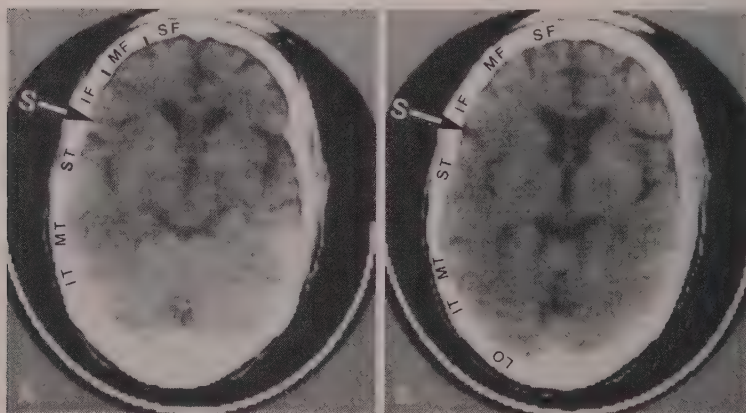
Gyral Anatomy.* A, Non-contrast-enhanced CT scan along reference line 3 clearly delineates the superior frontal gyrus (SF), middle frontal gyrus (MF), inferior frontal gyrus (IF) and the Sylvian fissure (arrow S). Compare with the opposite side. The superior temporal (ST), middle temporal (MT) and inferior temporal (IT) gyri are less clearly defined but are known to occupy the regions indicated. B, Non-contrast-enhanced CT scan along the next higher reference line 4 demonstrates the consistent gyral identification possible by CT. LO indicates the lateral occipital gyrus. Gyral identification may be carried out on serial CT sections utilizing the reference guides, until all the major gyri of the cerebral hemisphere have been delineated.
